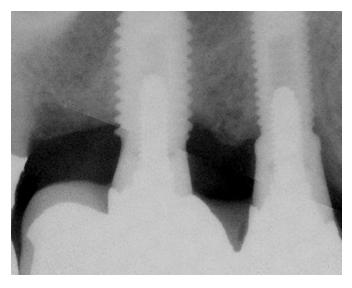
Periapical radiograph that was taken at the one-year post insertion recall appointment demonstrated bone levels consistent with the initial pre-operative radiograph.
